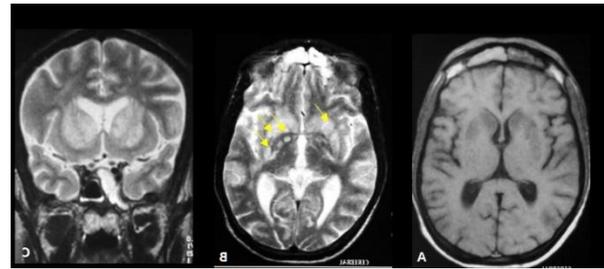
Cryptococcal infection: *Cryptococcus neoformans* pseudocysts and dilate perivascular Virchow-Robin spaces, non enhancing “cysts” seen symmetrically in basal ganglia (yellow arrows). These lesions are hypointense on T1W images (A) and hyperintense on T2W MR images (B,C).
